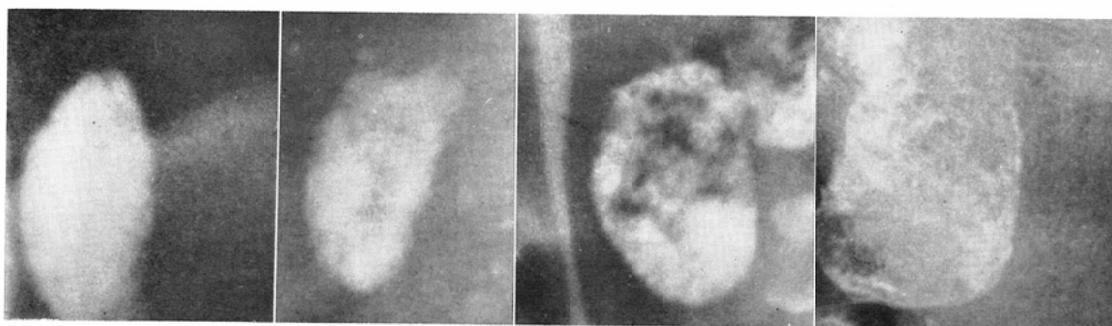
Standard roentgenograms for filling defects. From left to right: Grade 0 (no filling defects), Grade I (less than 1/3), Grade II (1/3 to 2/3), and Grade III (more than 2/3).
